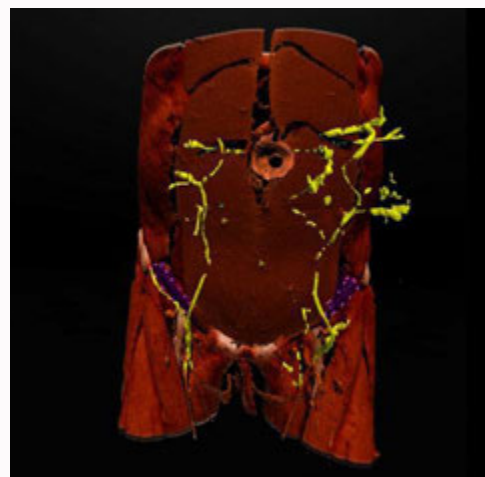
Post-op virtual reality 3D model based on patient's CTA prior to the procedure. Purple colored mesh encircled by pink dashed is marking the prolene mesh exact position.
